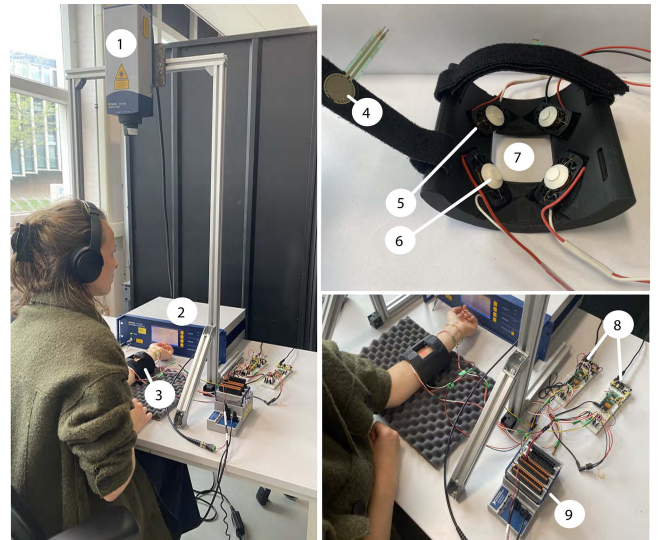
Experimental setup. It includes a laser doppler vibrometer with a sensor head (1) and controller (2) and the custom-designed wearable device (3), which consists of a force sensor (4), four voice-coil actuators (5) and closed-end cones (6), a square-shaped opening for skin-response measurements (7), voltage amplifiers (8), and a data acquisition board (9).
